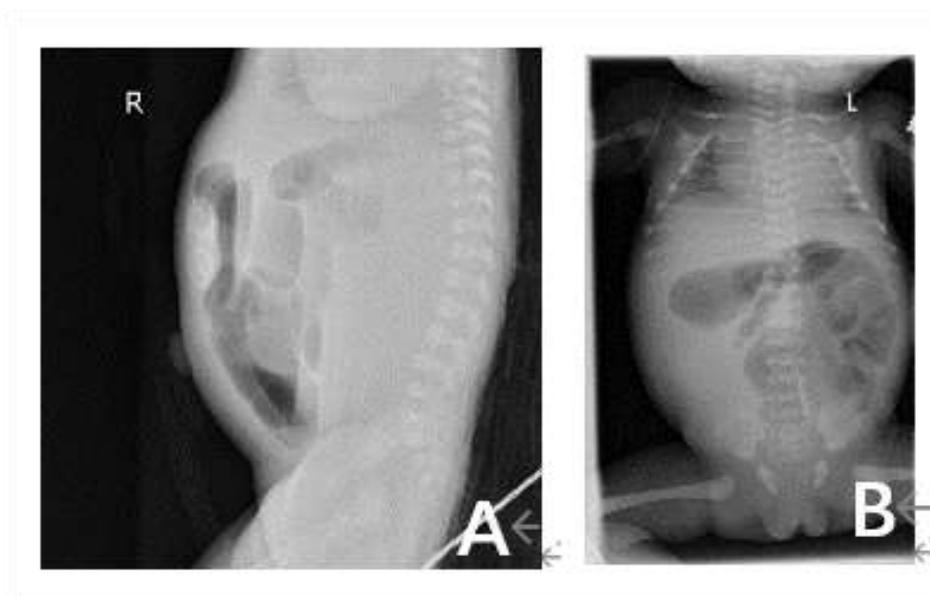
(A and B) The anteroposterior and anteroposterior plain films of the newborn's abdomen in case 1 show dilation and accumulation of gas in the abdominal intestines, with visible gas-liquid level. Intestinal obstruction has been considered.
